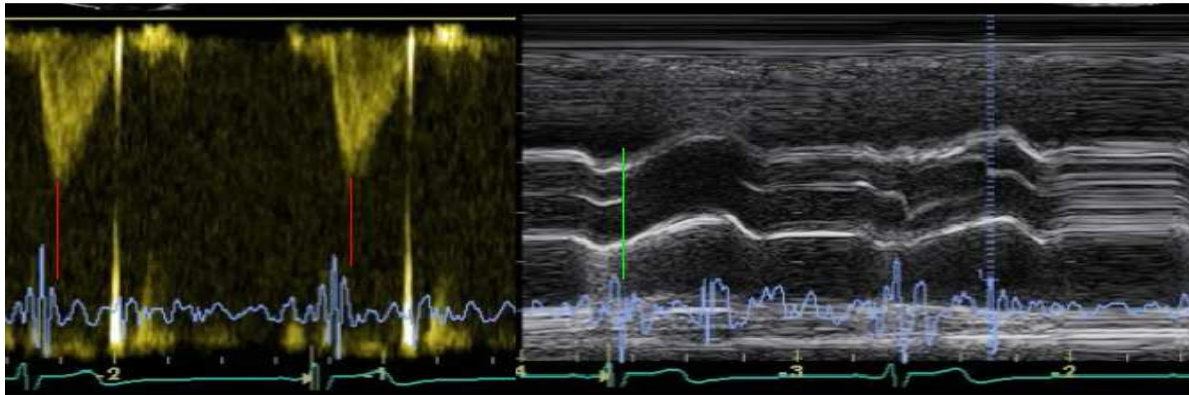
left: Doppler echocardiogram and SCG; right: M-mode echocardiogram
